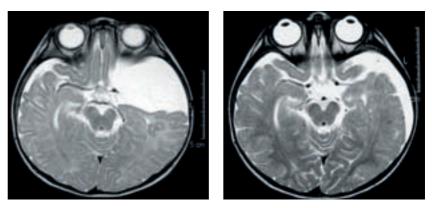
These MR images demonstrate a middle fossa arachnoid cyst prior (left) and 8 months after (right) a purely endoscopic fenestration in an infant who presented with divergent macrocephaly.
